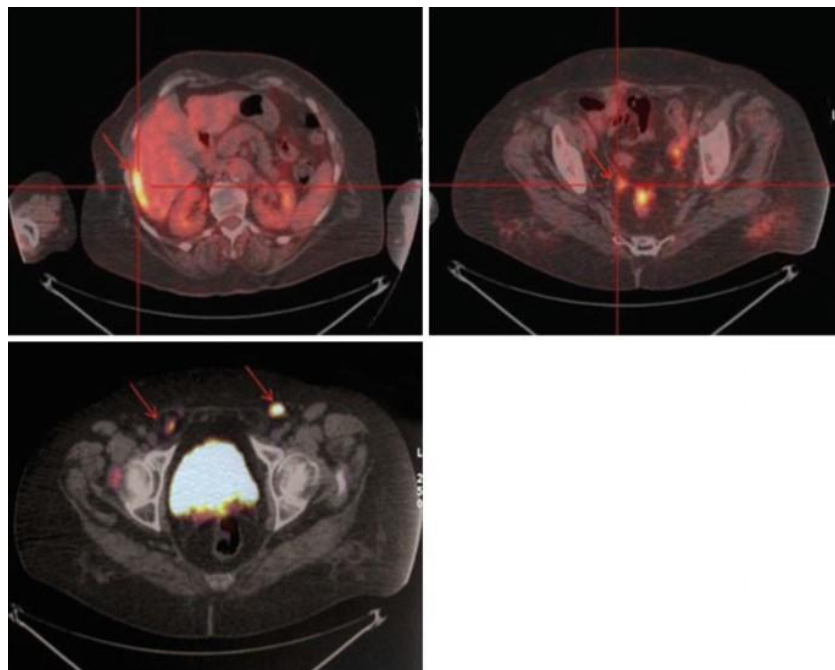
78-year-old woman post-treatment for ovarian carcinoma, presenting with rising tumor serum markers and negative findings on recent CT imaging. ^{18}F FDG-PET/CT revealed increased ^{18}F FDG uptake in the peritoneum and in bilateral inguinal lymph nodes [15].
